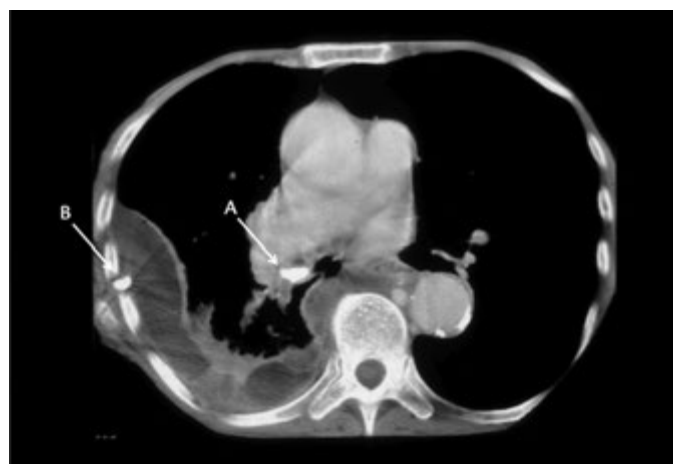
Thoracic CT scan showing an empyema complicating an aspirated foreign body (marked A). A piece of lamb chop was later removed at bronchoscopy. A chest drain is also seen (marked B).
